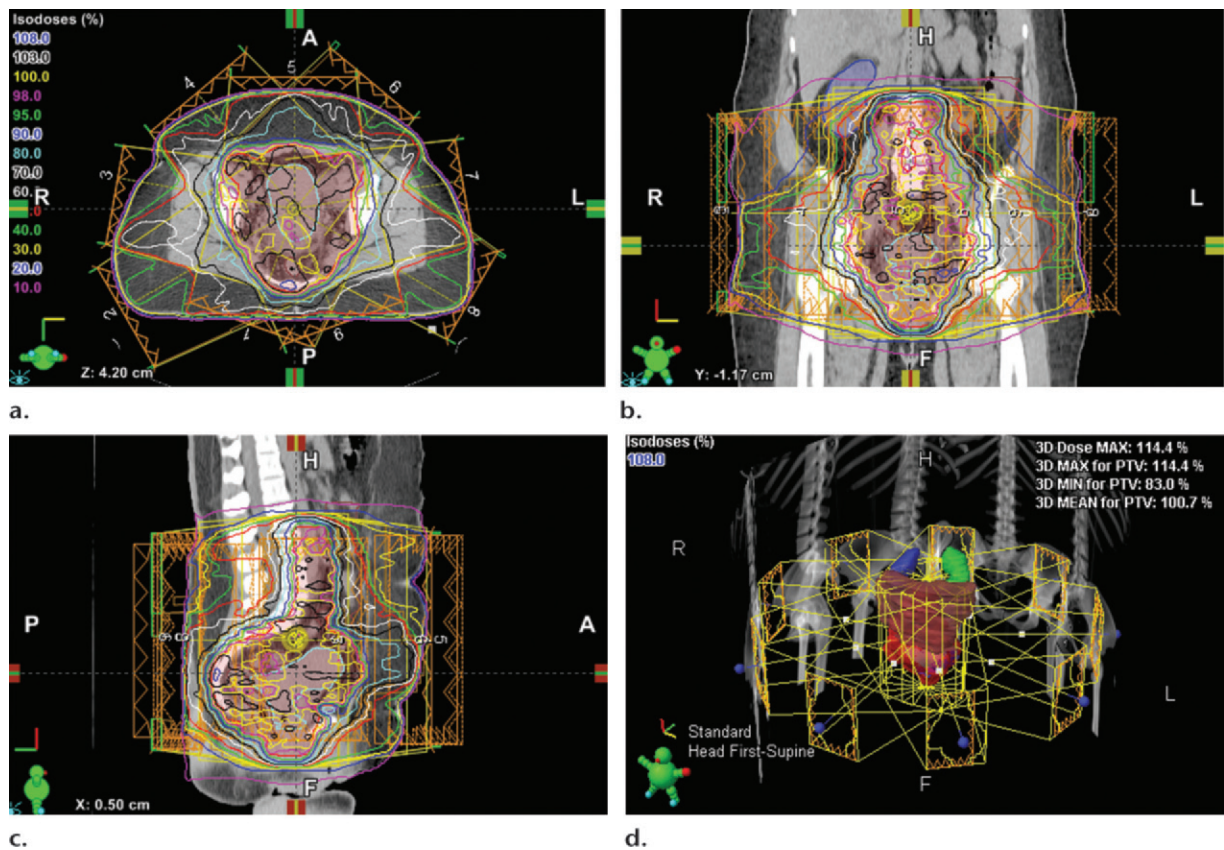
IMRT in a woman with cervical cancer. (a–c) Axial (a), coronal (b), and sagittal (c) views of treatment planning computed tomography (CT) show dose distribution with IMRT for cervical cancer. (d) 3D reconstruction with beam paths shows the use of multiple beam angles to achieve the fused dose distribution to focus on the planning target volume (PTV) (red area) and reduce the dose to the surrounding normal structures.
